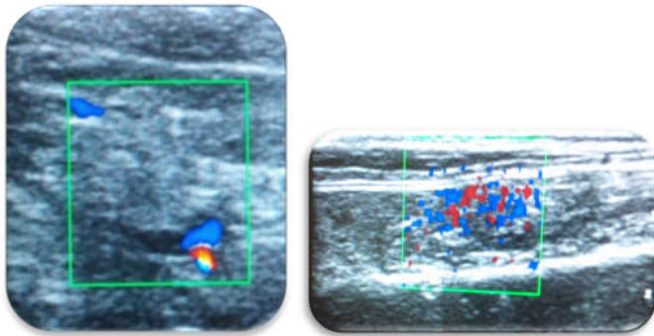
and 8 Color flow Doppler images of skin flap at 3rd, 7th and 14th day
